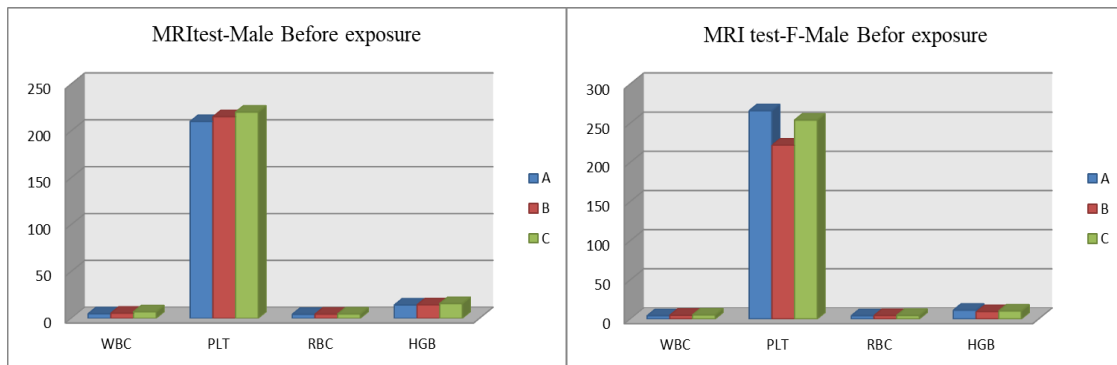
MRI test for Male & Female before exposures.
